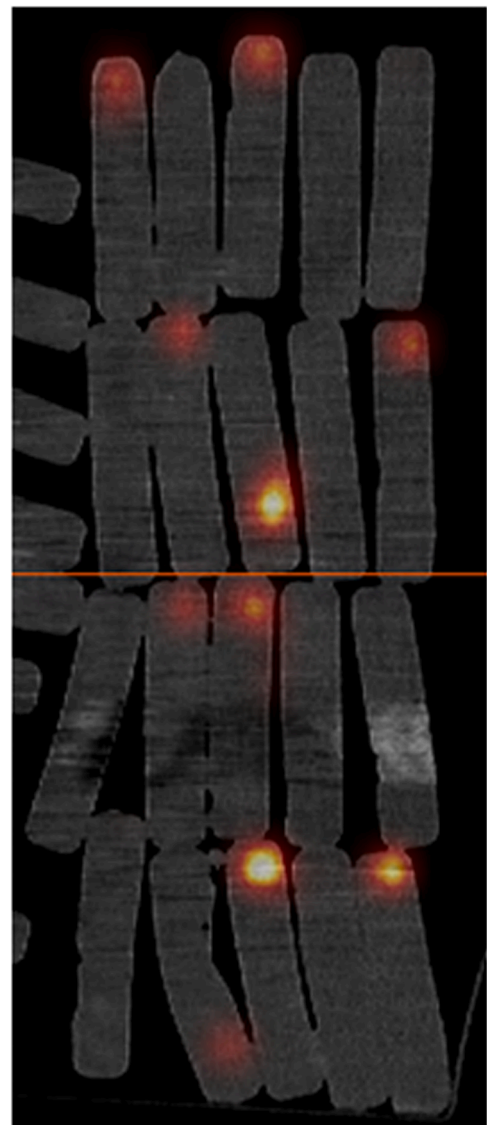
SPECT-CT of agar test objects showing hot spots where contaminated needle pierced.
